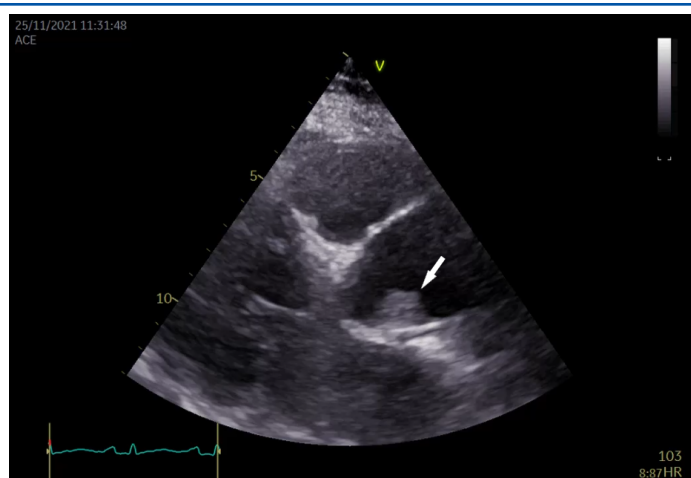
2D transthoracic echocardiography – parasternal long axis view. A mobile, irregular mass (arrow), 21/11 mm, attached to the aortic root wall at the level of the left sinus of Valsalva with no impact on the aortic valve.
